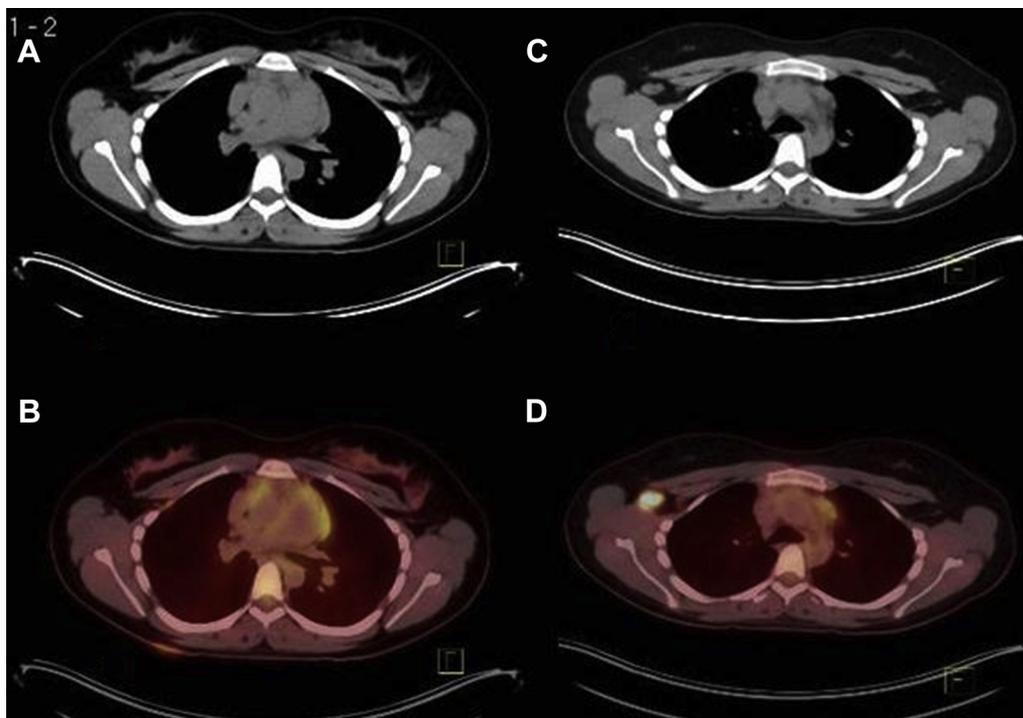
Axial computed tomography (CT) and fused positron emission tomography/CT images of the chest showing focal skin thickening and increased 2-deoxy-2-[18F]fluoro-D-glucose uptake overlying the right scapula (A, B) in addition to the hypermetabolic right axillary adenopathy (C, D).
